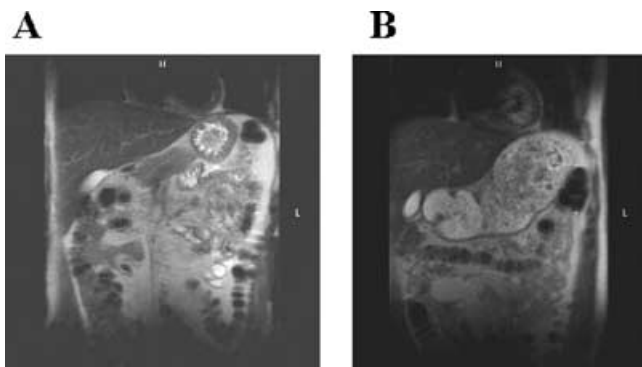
Examples of MRI imaging of gastric contents in a normal subject in supine position during fasting (A) and after a liquid-solid meal (B).
